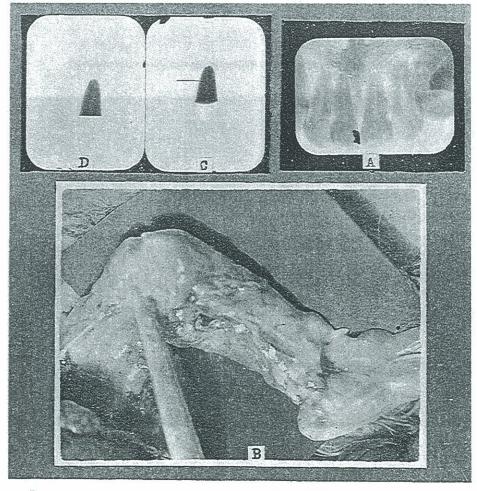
A roentgenographically innocent tooth, but actually a very dangerous one.
